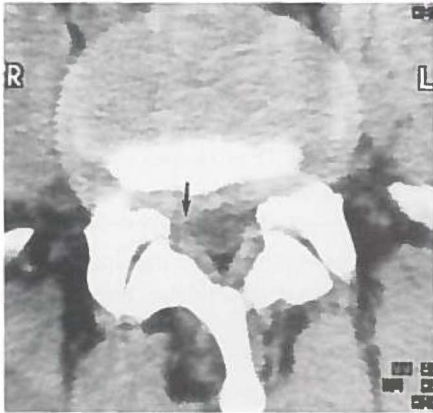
Case 5. CT scan at the same disc level, 12 months after chemonucleolysis: it is not clear whether there is still slight disc protrusion on the right (arrow), compared with the CT scan at three months. The interpretation of the focal abnormality may be complicated by the increased annular bulging (compare to Fig. 3.5).
